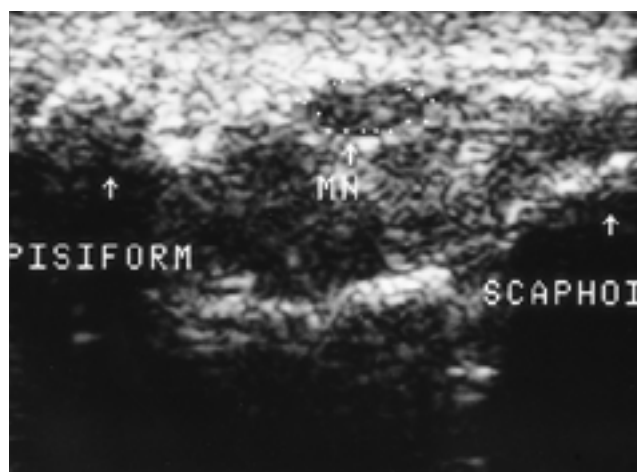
A 51-year-old woman with carpal tunnel syndrome. Axial sonogram of wrist at pisiform level shows enlarged hypoechoic median nerve. Cross sectional area of the median nerve is measured as  $15.3 \text{ mm}^2$ .
